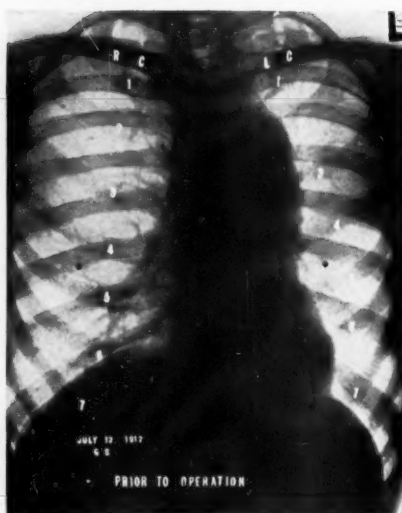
Patient G. S., X-ray of July 12, 1912, before operation, Direct anteroposterior view. (Taken by Dr. Leon T. LeWald.)
